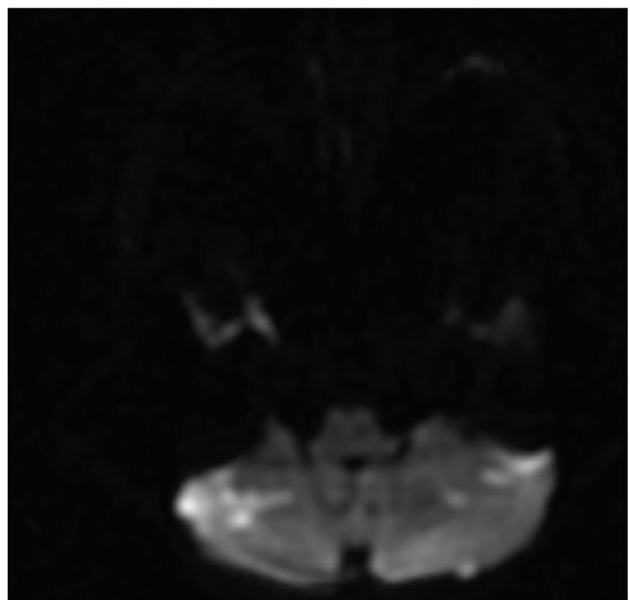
MRI diffusion-weighted imaging showing multiple hypodensities in the cerebellum.
